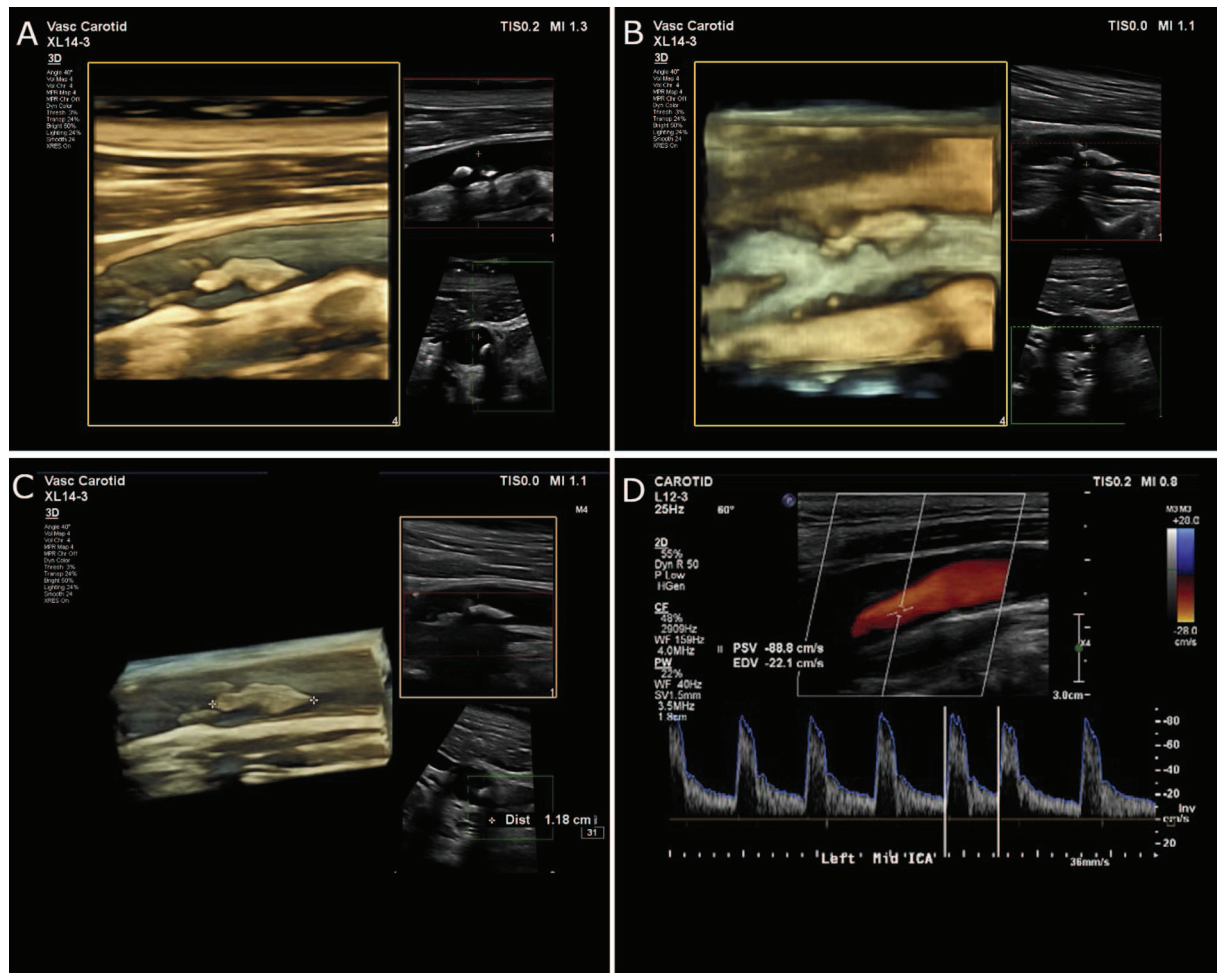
3D plaque acquisition. Three-dimensional imaging of the carotid artery, providing plaque lesion morphology. A-C: Images acquired by a matrix array vascular probe of the left carotid artery. D: The protocol was preceded by a two-dimensional image and Doppler velocity assessment that suggested 40% stenosis. The three-dimensional images demonstrated the complexity of the arterial plaque, not appreciated by two-dimensional imaging. Three-dimensional imaging may explain why the velocities were lower than expected, by detailing the complexity of the plaque and identifying additional flow channels through the body of the lesion not visualized by two-dimensional imaging. The degree of protuberance seen by three-dimensional imaging was also not appreciated by two-dimensional imaging alone.
